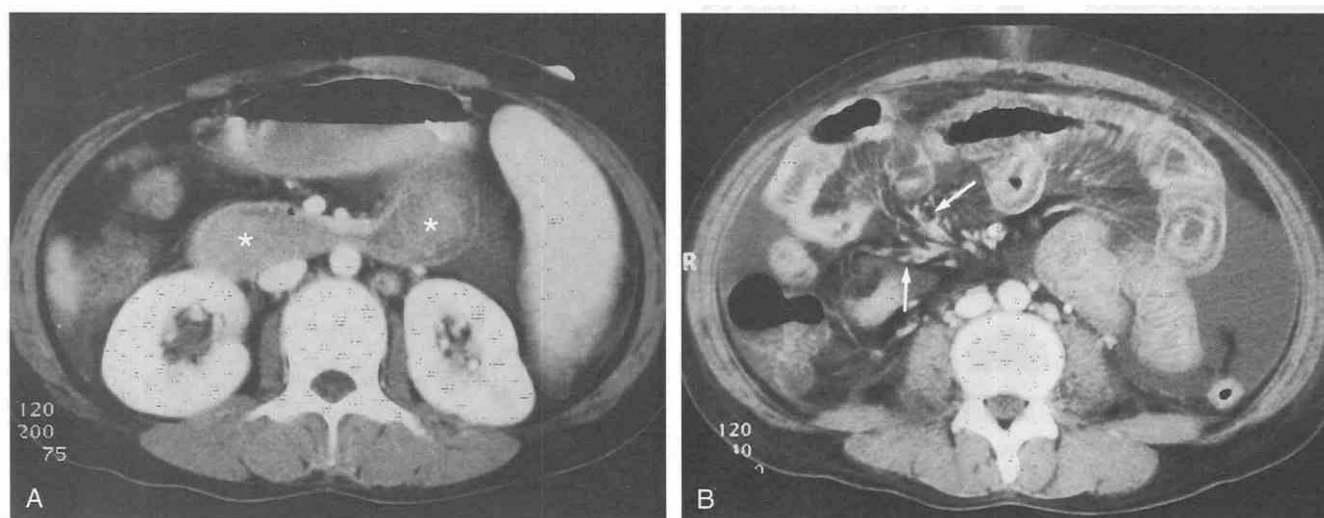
Systemic lupus erythematosus. A, CT scan shows edematous gastric wall thickening (*asterisks*). B, The duodenal and ileal walls are also similarly thickened (*arrows*). (From Ha HK, Lee SH, Rha SE, et al: Radiologic features of vasculitis involving the gastrointestinal tract. *Radiographics* 20:779-794, 2000.)
